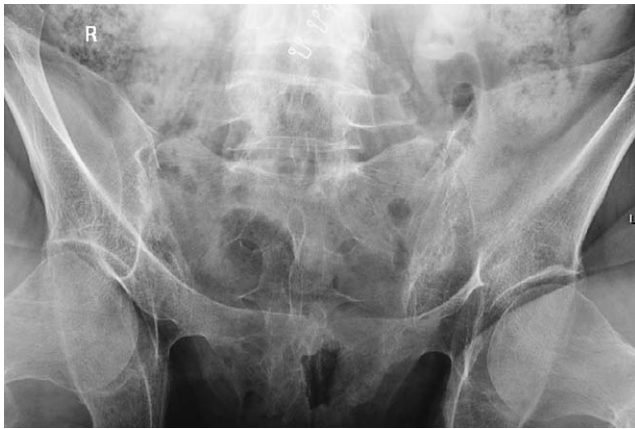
Anteroposterior radiograph oblique view of sacroiliac joints showing partial ankylosis of both SI joints defined as grade III sacroiliitis by the New York criteria
